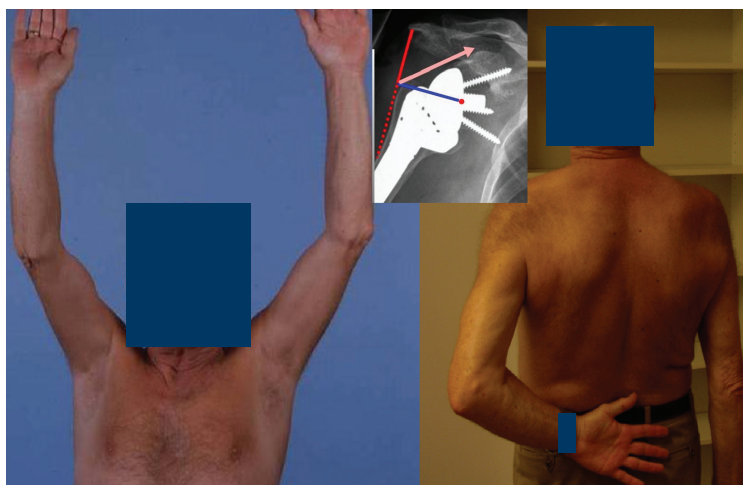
Typical clinical outcome after 7-year follow-up of reverse shoulder arthroplasty of the right shoulder. Excellent abduction and flexion, some limitation in internal rotations. Plain film insert shows significant medialization and lowering of the center of rotation and the increased deltoid lever arm (blue bar).
